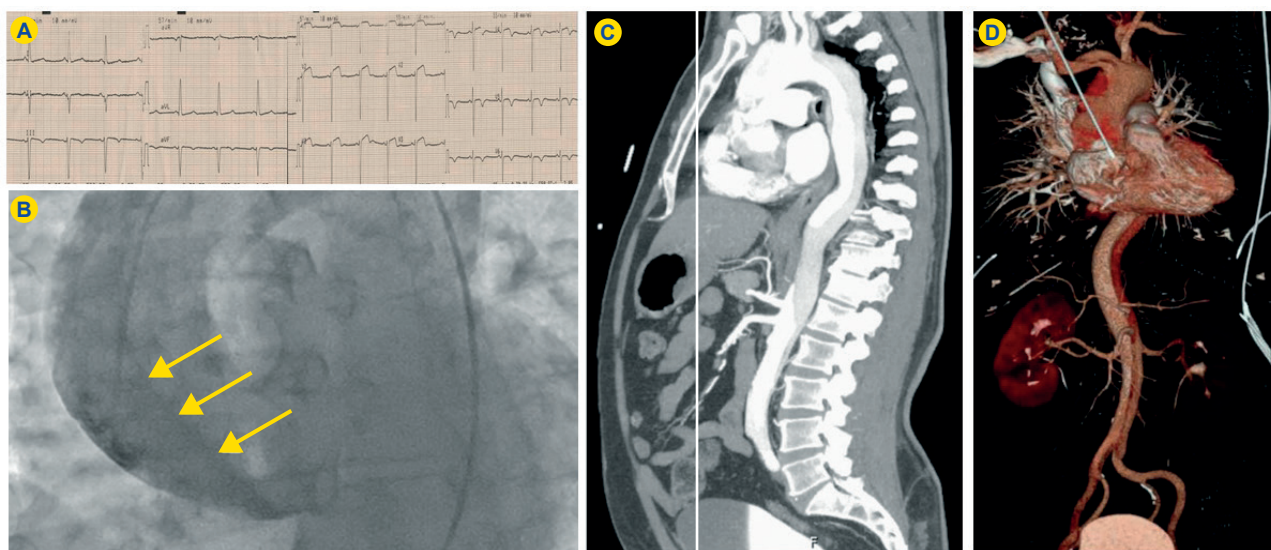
Admission eletrocardiogram showing 1 mm ST elevation in V1-V2 and T wave inversion in V5-V6 (A); Aortic angiogram revealing an aortic flap (B, arrows); Thoracic and abdominal angio-CT scan confirming type A aortic dissection (C); 3D reconstruction of thoracic and abdominal angio-CT scan (D).
